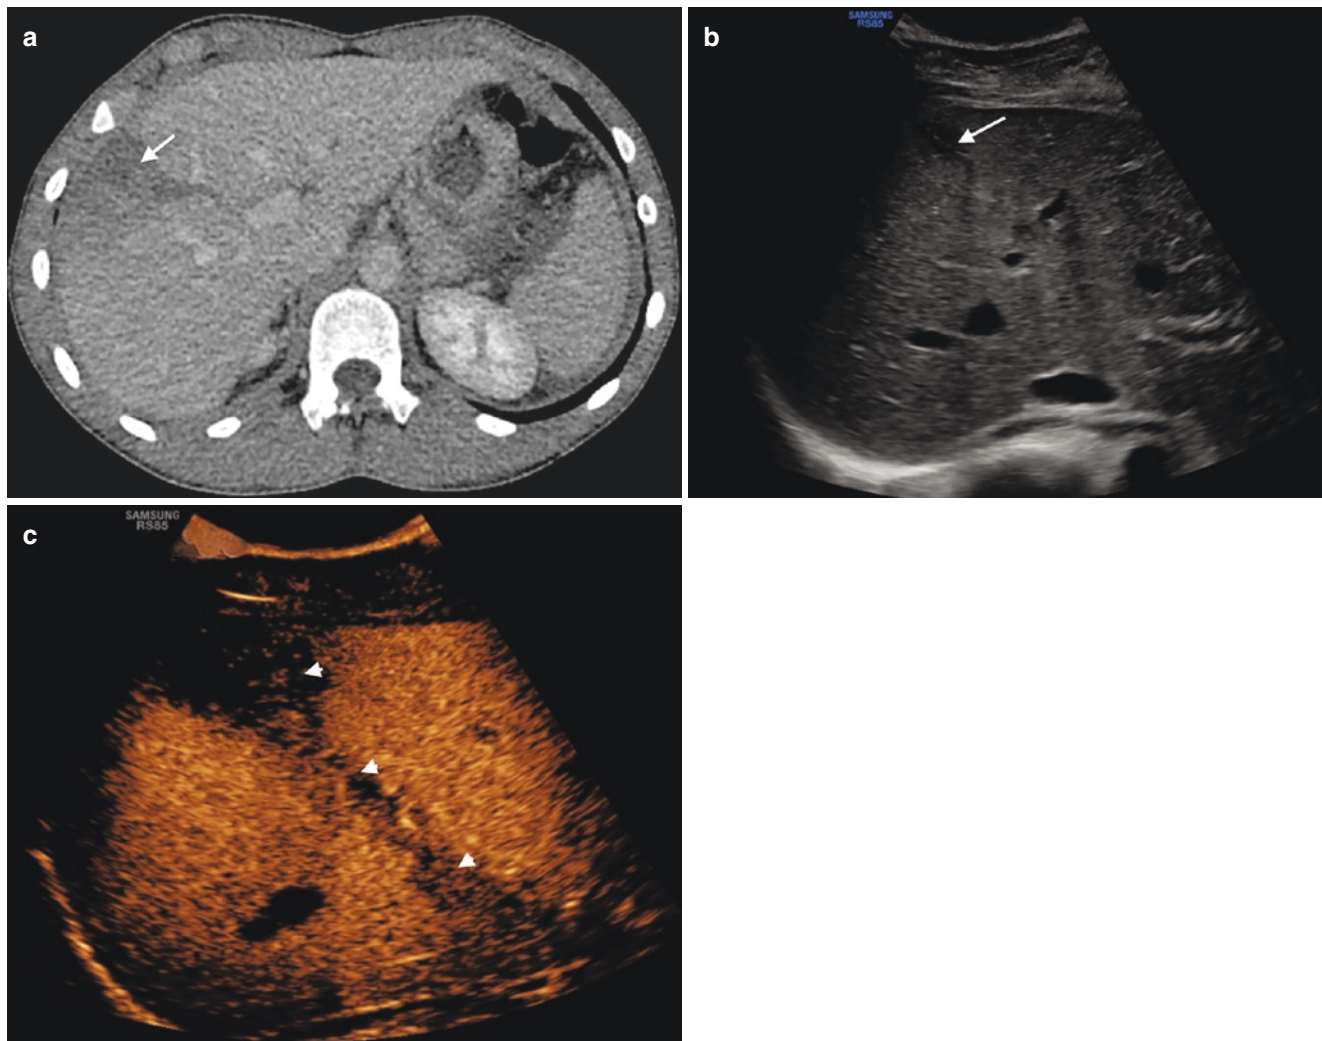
(a) Axial CT image of the liver demonstrates a liver contusion/laceration that extends to the hilum (*arrow*). (b) Follow-up B-mode image of the liver shows a small focal hypoechoic area in the periphery
